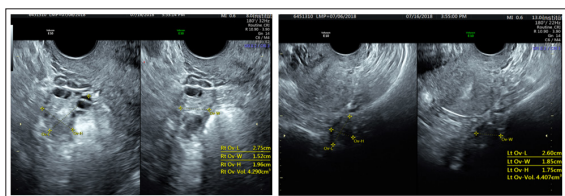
A dermoid focus seen on the right ovary in the Transvaginal ultrasound in 2018
